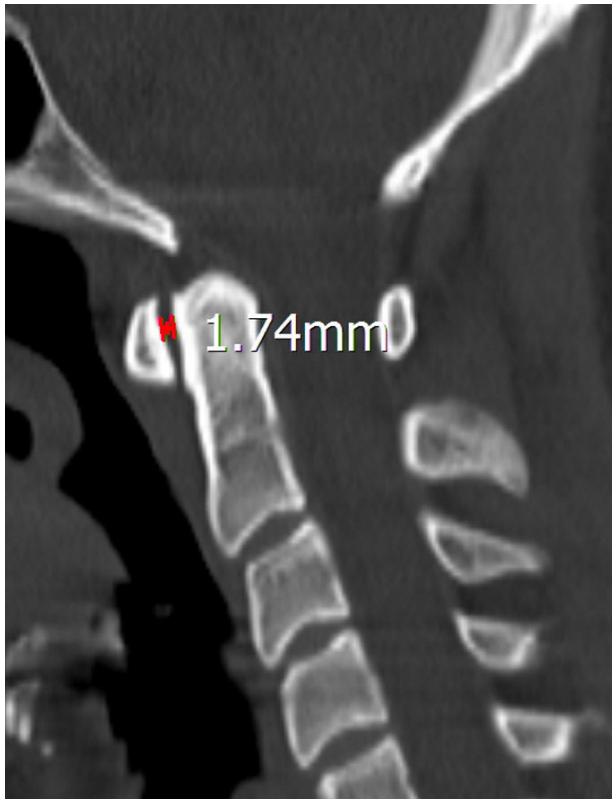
The atlantodental interval was measured as the distance between the posterior border of the anterior C-1 arch and the anterior margin of the odontoid process on a midline sagittal CT image.
